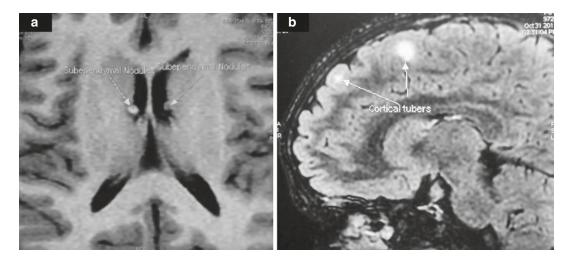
MRI brain of a patient with TSC. Subependymal nodules (a) and cortical tubers (b). (Image courtesy: Dr. Vikas Khetan)
